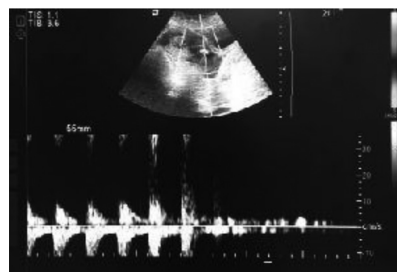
Doppler wave form of the pulsating artery
